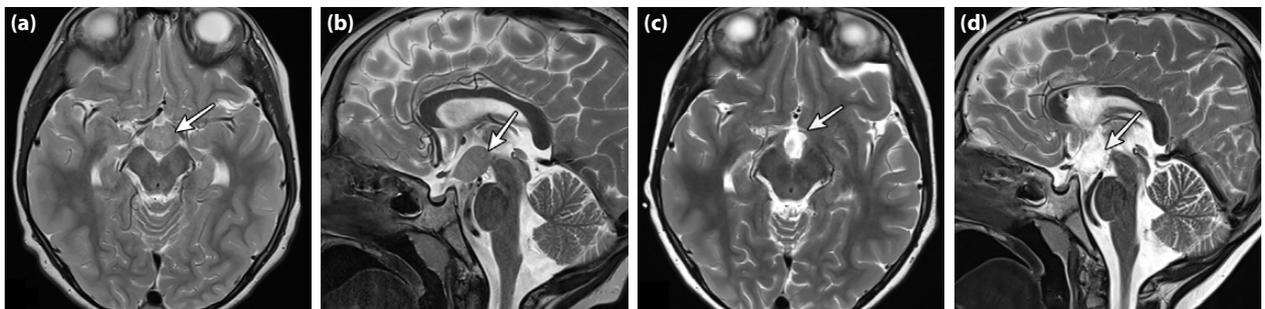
(a) Axial section T2 weighted MRI of a patient with type 2 HH (arrow). (b) Sagittal section T2 weighted MRI of the same patient (arrow). (c) Axial section T2 weighted MRI of the patient after disconnection surgery through the interhemispheric route. Arrow designates disconnection plane. (d) Sagittal section T2 weighted MRI of the same patient after disconnection surgery. Arrow designates the disconnection plane.
